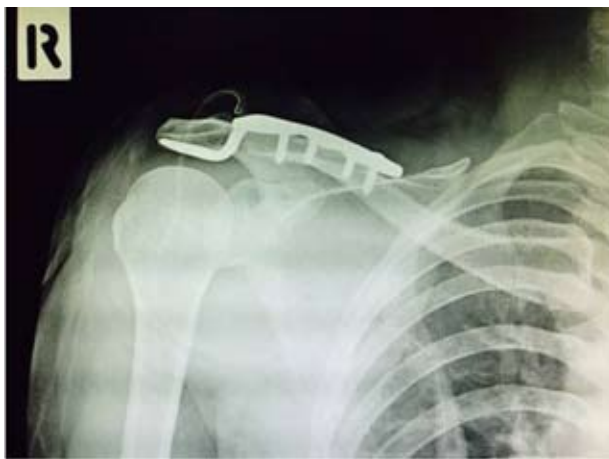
A postoperative radiograph demonstrating a reduction at acromioclavicular joint using a 5-hole hook plate.
